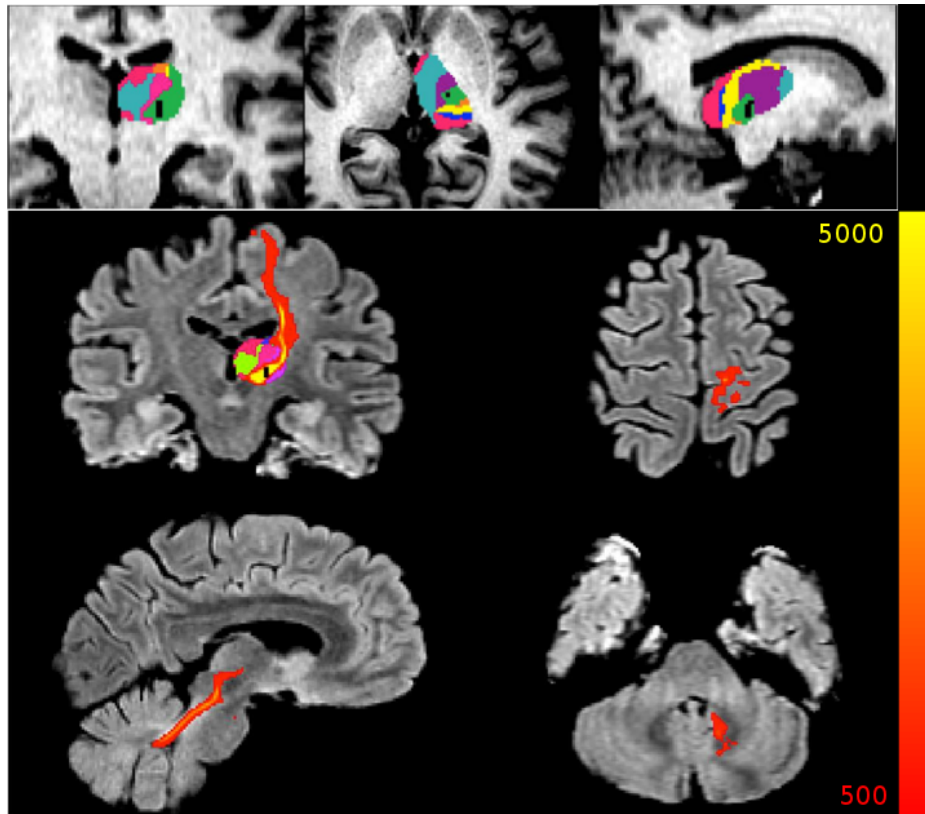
Preoperative FLAIR images show perirubral mesencephalic traumatic hemorrhage (dark area pointed by arrows). Probabilistic multi-fiber diffusion tractography, initiated from the thalamotomy lesion to the whole brain as a target, showed connections to the premotor cortex, nucleus ruber and the perirubral mesencephalon. Some tracts reach the ipsilateral cerebellar hemisphere too. Image is thresholded at 500 particles (10%).
